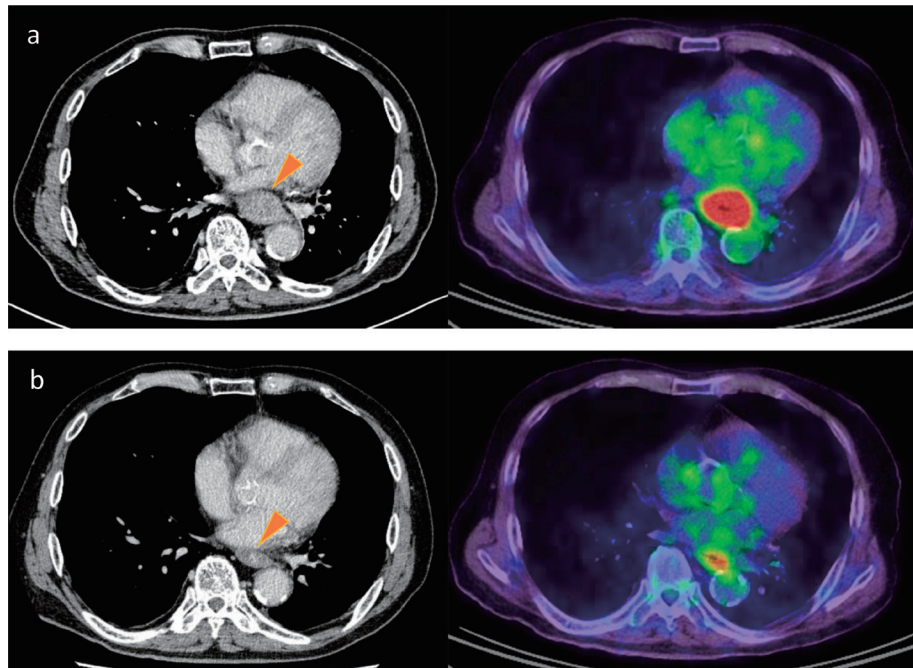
Computed tomography (CT) and positron emission tomography-CT (PET-CT) findings.
